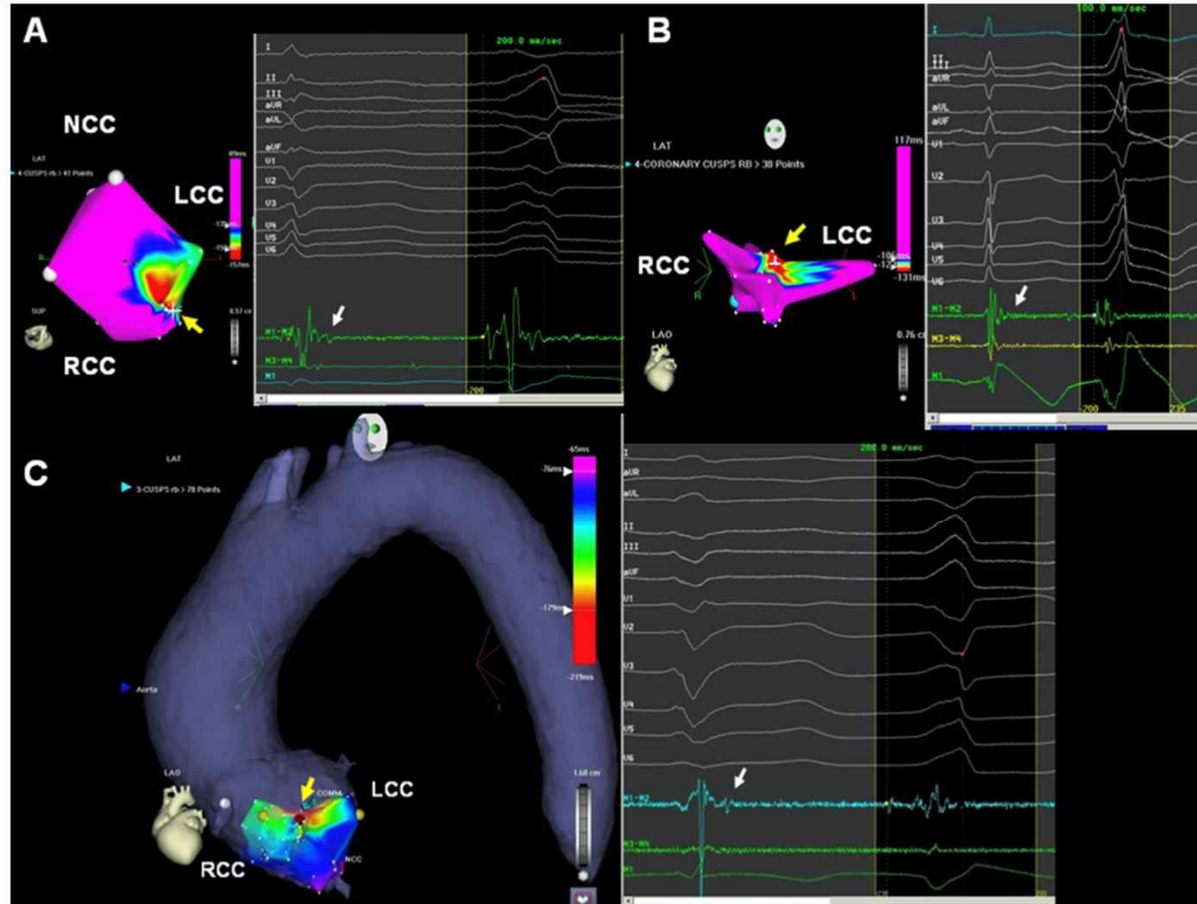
A-C: Activation maps coupled with recordings in sinus rhythm and ventricular premature depolarizations from three patients with site of origin at the right coronary cusp-left coronary cusp (RCC-LCC) commissure. The anatomic location was confirmed by intracardiac echocardiography. *White arrows* on the electrogram recordings indicate late potentials in sinus rhythm that transitioned to presystolic activation during wide-complex ventricular premature depolarizations. In panel C, the activation map of the aortic cusp region was merged with a computed tomographic angiogram (CTA). The site of origin of the ventricular premature depolarization is indicated by the *yellow arrow*. NCC = noncoronary cusp.
